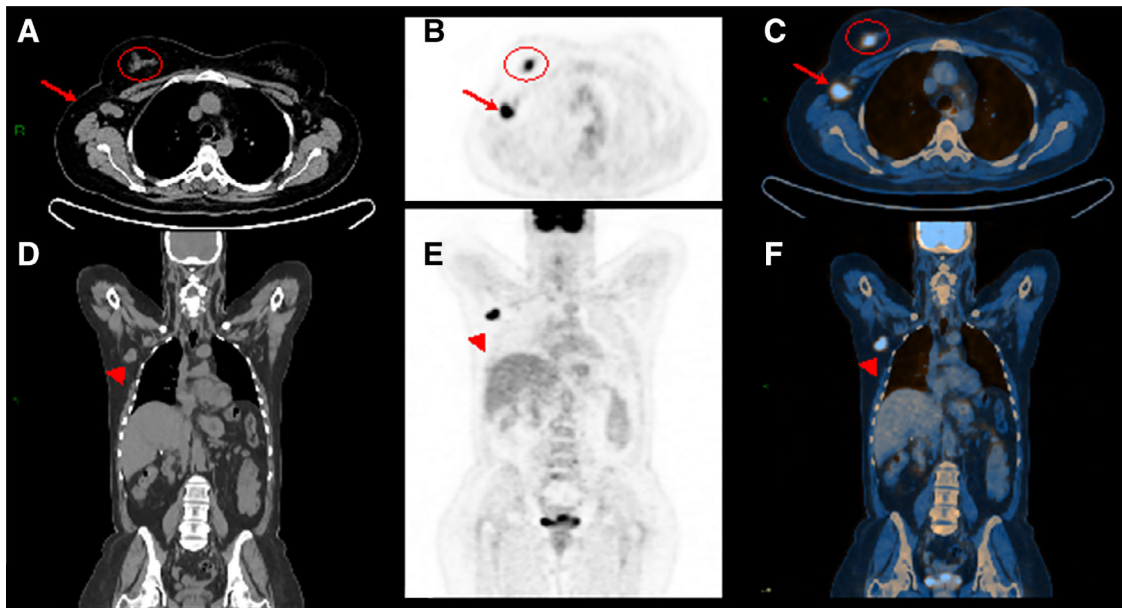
A woman aged 45 years with invasive ductal cancer of the right breast. Computed tomography (CT) of the whole body. Axial (A) and coronal (D) views show enlarged node in the right axilla (A, arrow; C) associated with an irregular mass within the right breast (A, circle). Whole body positron emission tomography (PET) examination. Axial (B) and coronal (E) views demonstrate high fluorodeoxyglucose uptake for both the mass and the enlarged node in the axilla that is also confirmed by hybrid imaging PET/CT (C, F).
